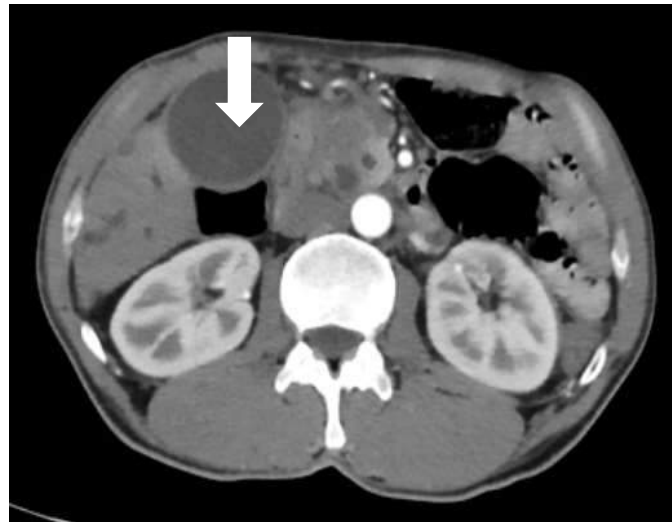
Multislice Triphasic CT of Abdomen & pelvis axial view, with contrast for a 50years old male patient)
